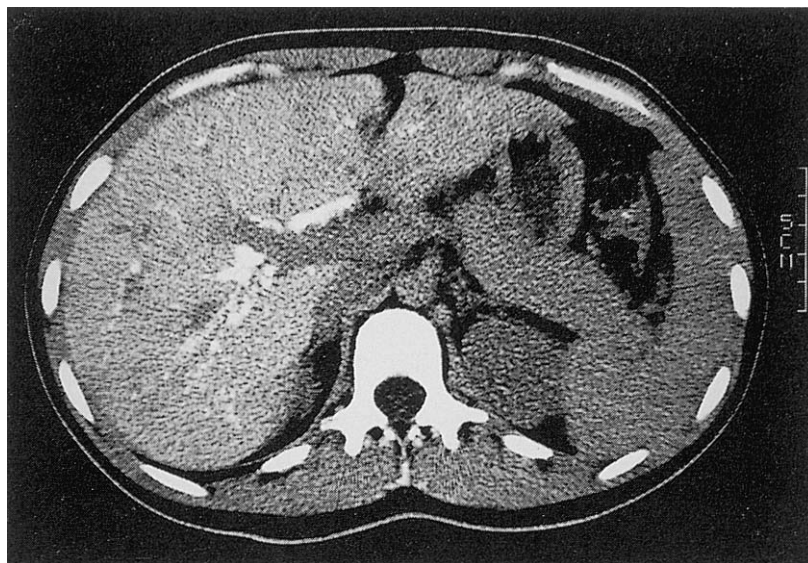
A 24 year-old female who suffered recurrent cholangitis 2 years ago. CT imaging revealed the dilatation of the left intrahepatic bile duct (IHBD) and a stricture at the anastomotic site.
